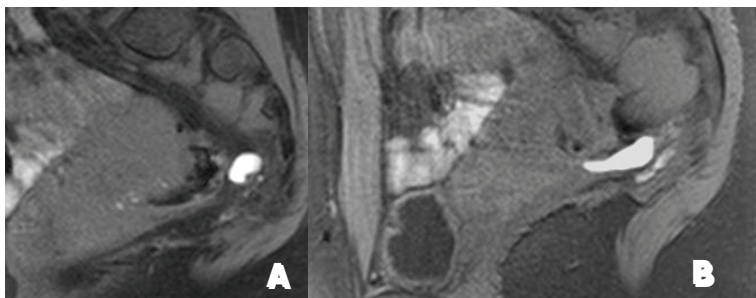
Fat-suppressed T1-weighted images demonstrate hyperintense spots that correlate with hemorrhagic endometrial implants on the ligament (A, B).
